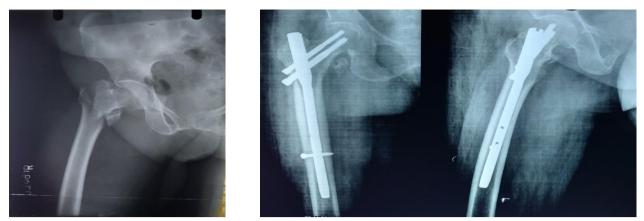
Pre and Post-operative Radiograph of Type II Fracture at 6 month follow up
